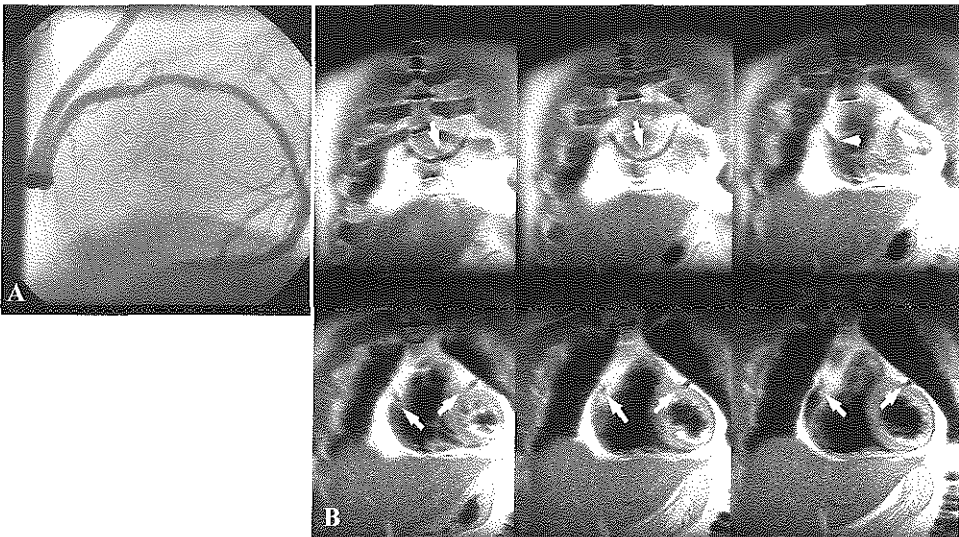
(A) Cardiac triggered, free-breathing 2D single-shot blackblood fast SE (HASTE) technique for coronary bypass graft localization. (B) Conventional X-ray contrast angiogram of a 50-year-old patient with previous myocardial infarction and presently recurrent angina and with a venous jump graft from the aorta to the left anterior descending, diagonal, intermediate, and marginal branches, and the posterior descending artery. Six sections from 30 collected over 2 min during free-breathing. A single slice of the HASTE technique is acquired every three heartbeats with a time resolution of 395 ms per shot (TE = 30 ms, interecho spacing = 3.8 ms, 5-mm slice thickness, 1-mm overlap, 192 × 256 matrix, FOV = 350 × 350 mm²). (see also Figs. 21, 22)
